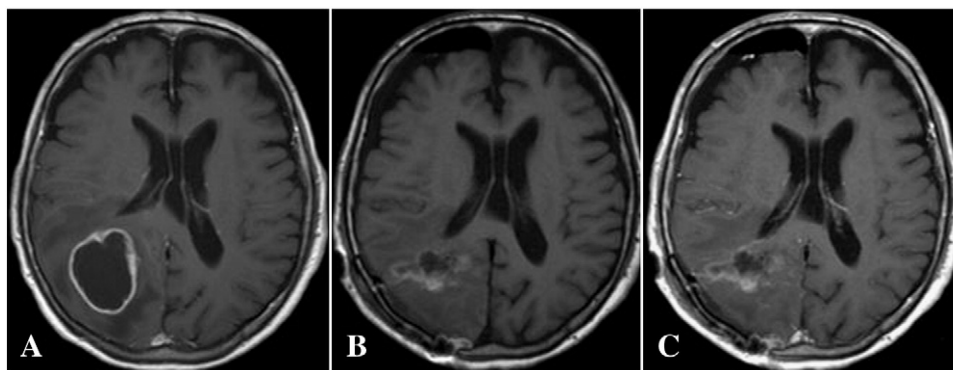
Magnetic resonance images. A: Preoperative enhanced T1-weighted image showing a metastatic brain tumor in the right occipital lobe. B: T1-weighted image 1 day after surgery showing no residual tumor. C: Enhanced T1-weighted image 1 day after surgery, also showing no residual tumor.
